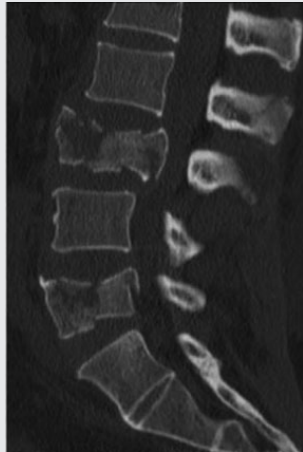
Computerised tomography (CT) sagittal view: level III and level V burst fractures.
